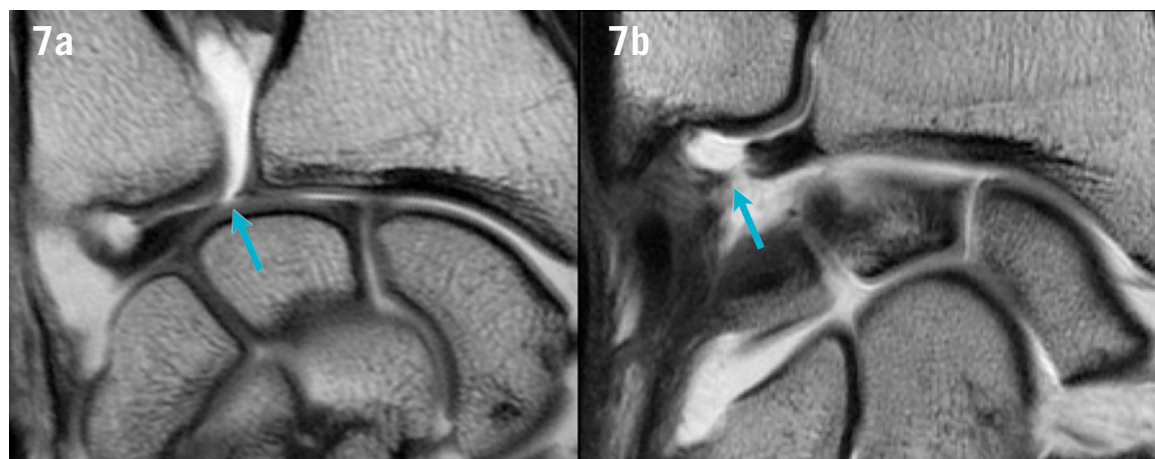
MR arthrography in coronal T1-weighted sequence from two different patients shows central a) and ulnar-sided b) tear.
